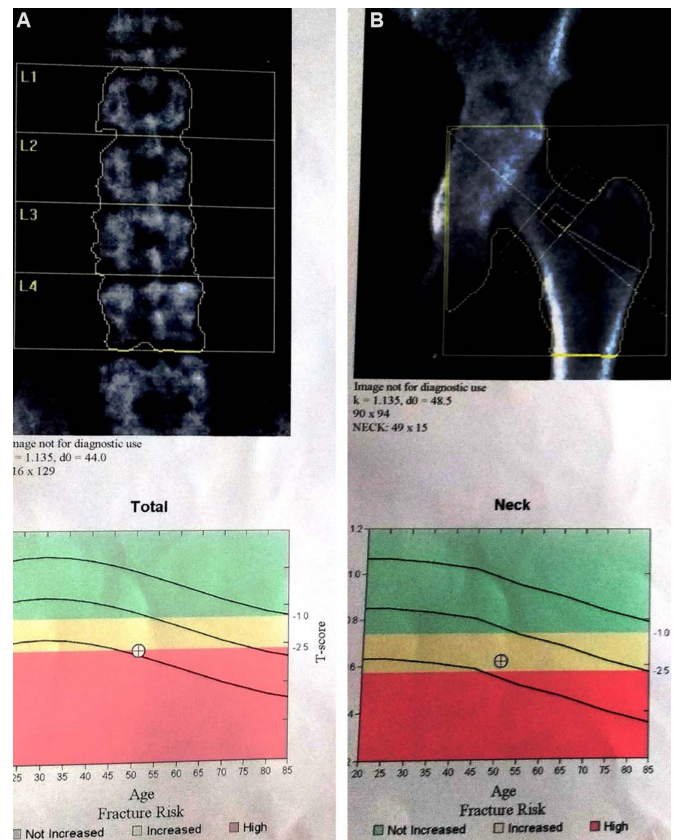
Dual-energy X-ray absorptiometry (DEXA) scan images of lumbar spine (A) and hip joint (B) showing osteopenic changes with reduced T-scores.
